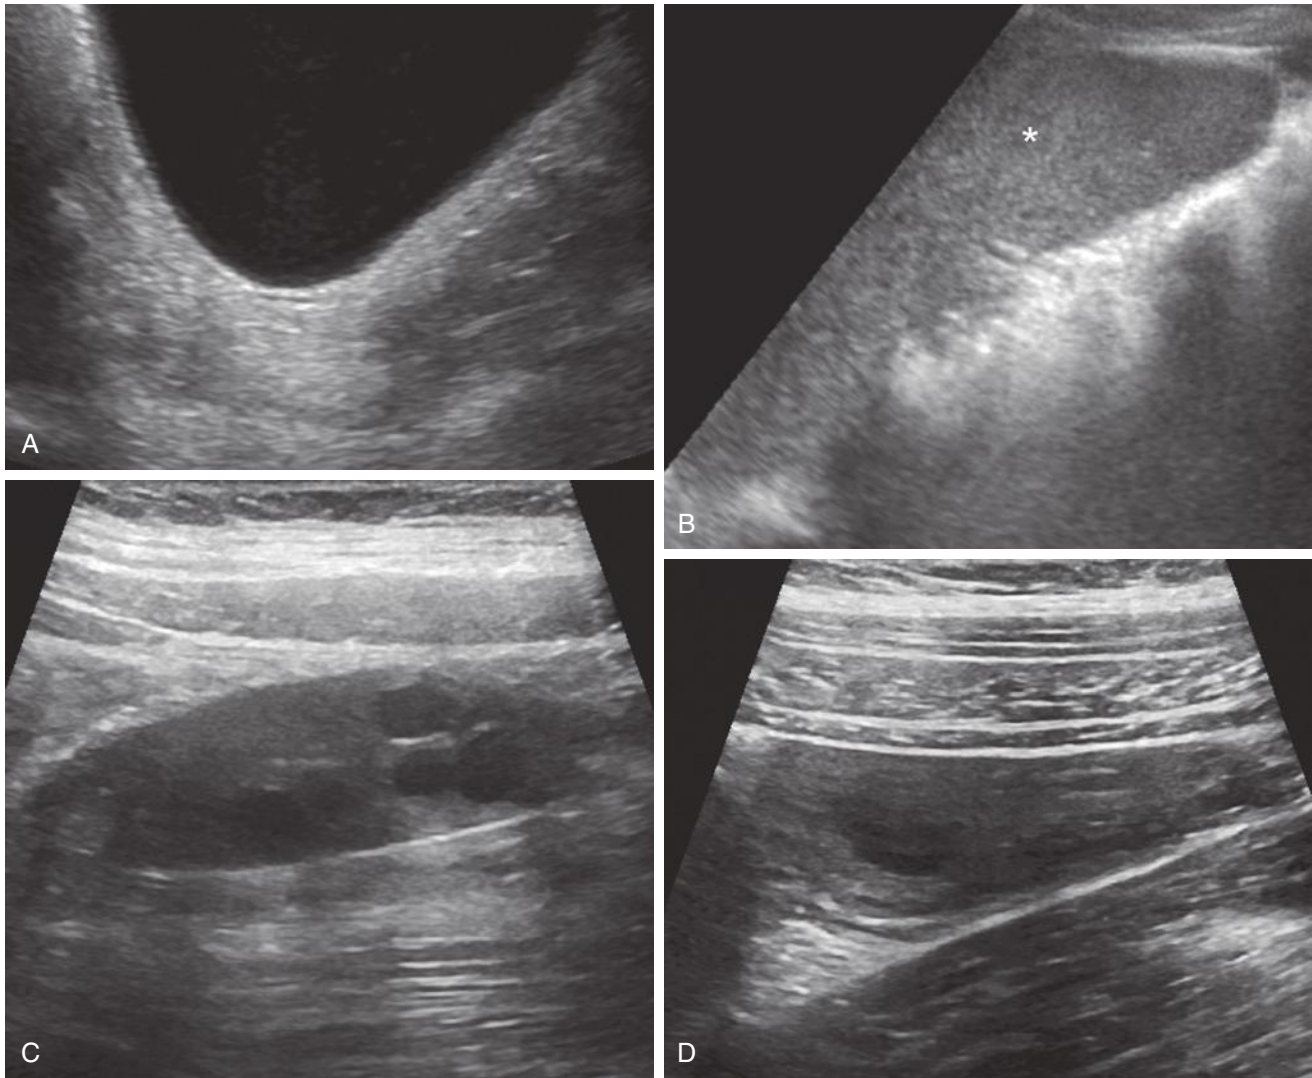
Vaginal agenesis in a 17-year-old girl with primary amenorrhea. A, Sagittal midline ultrasound image reveals no evidence of a vagina or uterus. B, The left kidney was absent, with an empty renal fossa depicted on a sagittal ultrasound image of the left upper quadrant. The spleen is indicated by an asterisk. Normal right (C) and left (D) ovaries were identified.
